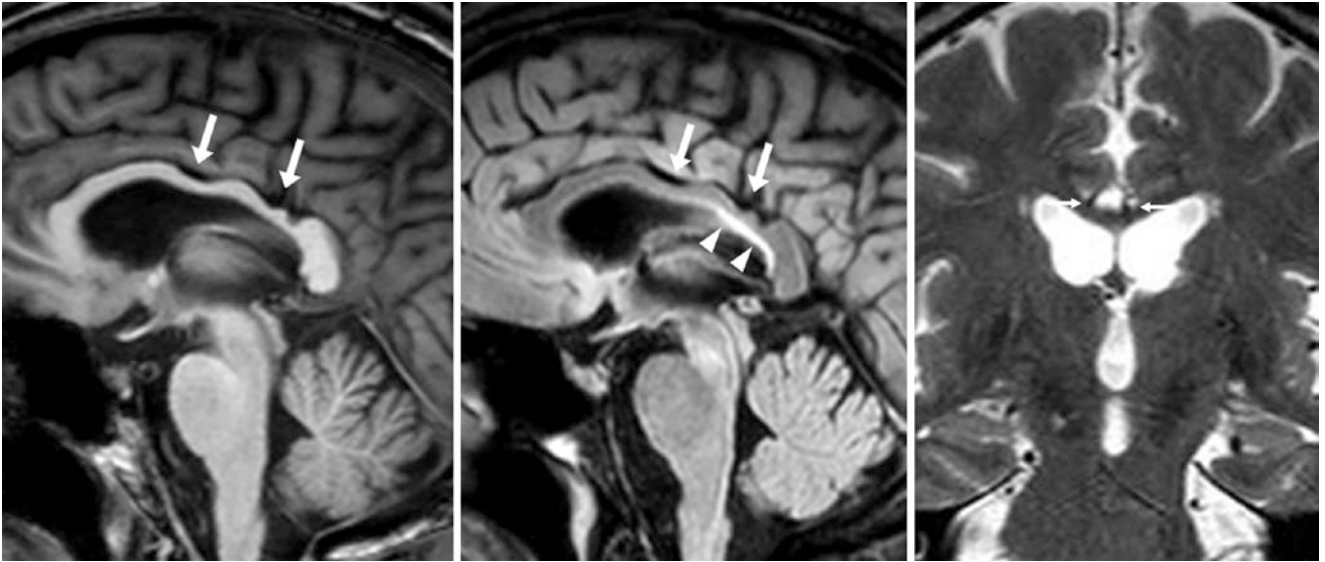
A 35 year old who underwent with a 3T MRI (negative) demonstrating mild compression (*arrows*) of the midposterior callosal body from pericallosal arteries (*thin arrows*) on a midline sagittal T1WI (*left*), FLAIR (*middle*), and coronal T2WI (*right*). Note the normal callosal-septal interface signal (*arrowheads*) on FLAIR, which is oriented parallel to the ventricular margin
